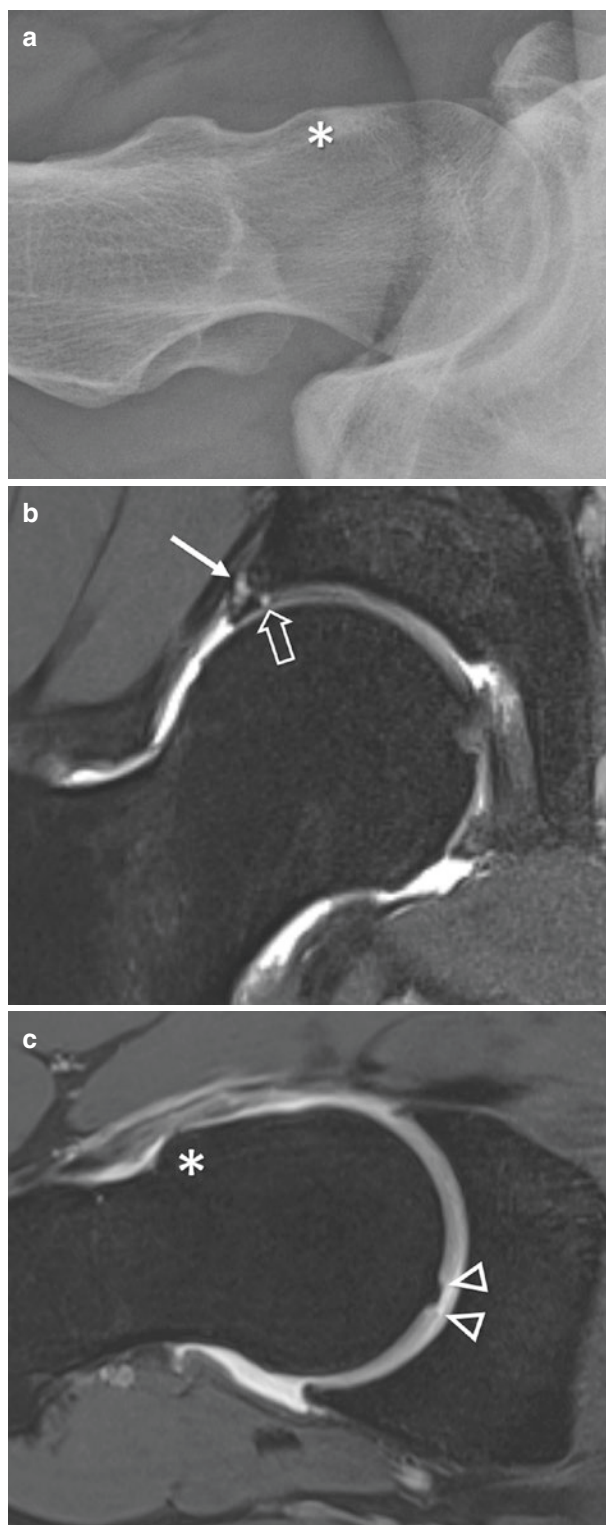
Cross-table lateral radiograph (a) of the right hip in a 32-year old male competitive fencer with femoroacetabular impingement showing a large anterior cam deformity (asterisk). Coronal PD fat-suppressed (b) MR image demonstrates full-thickness labral tear with intra-substance ganglion (thin arrow) and adjacent peripheral defect of acetabular cartilage (outline arrow). Oblique axial T2 fat-suppressed (c) MR image shows an intra-cartilaginous osteophyte and adjacent central cartilage defects of the femur (arrowheads) as well as the cam deformity (asterisk)
